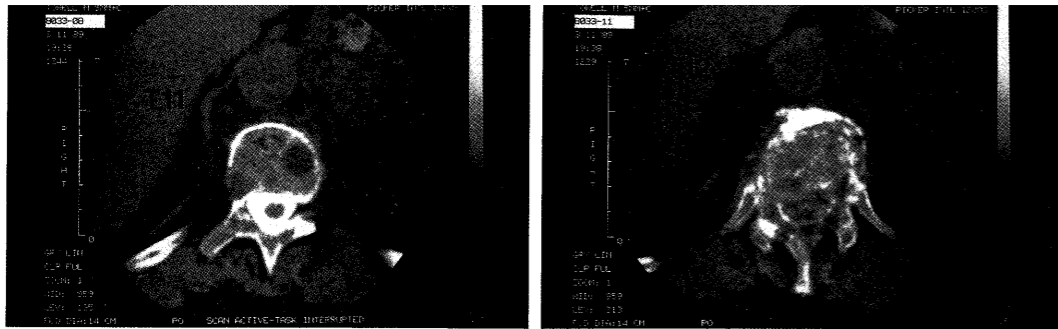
CT scan - metastatic breast cancer with secondary at T11 - T12
